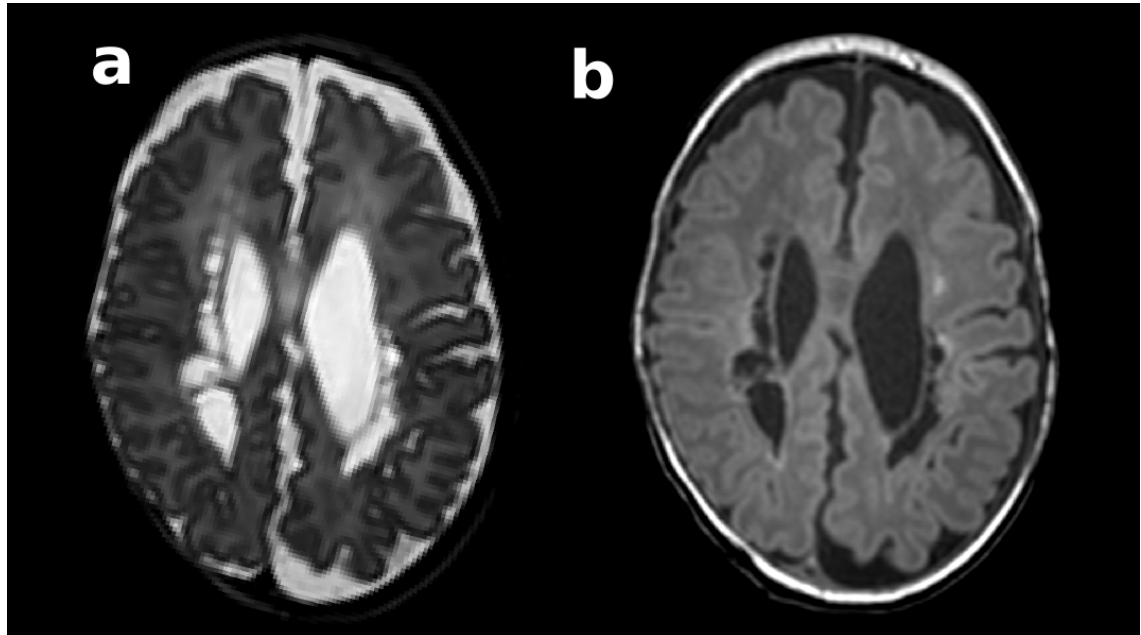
Cystic PVL in a preterm infant. Axial T2- (a) and T1-weighted (b) images of an infant born at 31.2 weeks GA and imaged at 42.7 weeks PMA.
